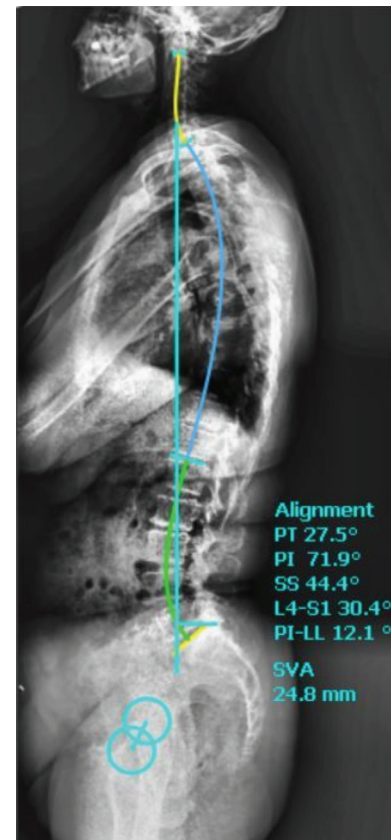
Preoperative lateral spine radiograph of patients treated with short level fusion surgery
